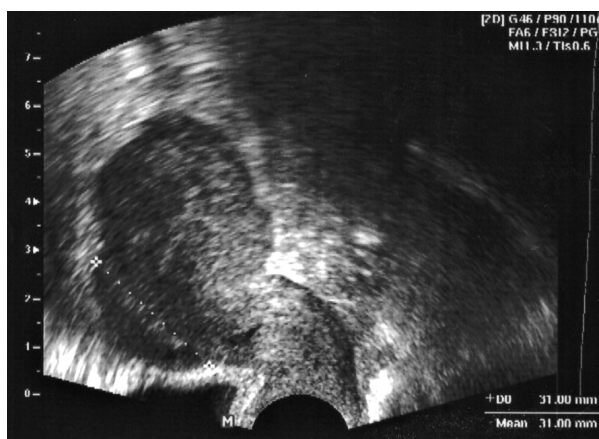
Transvaginal ultrasound before surgery shows an echogenic formation in the area of the uterine incision
